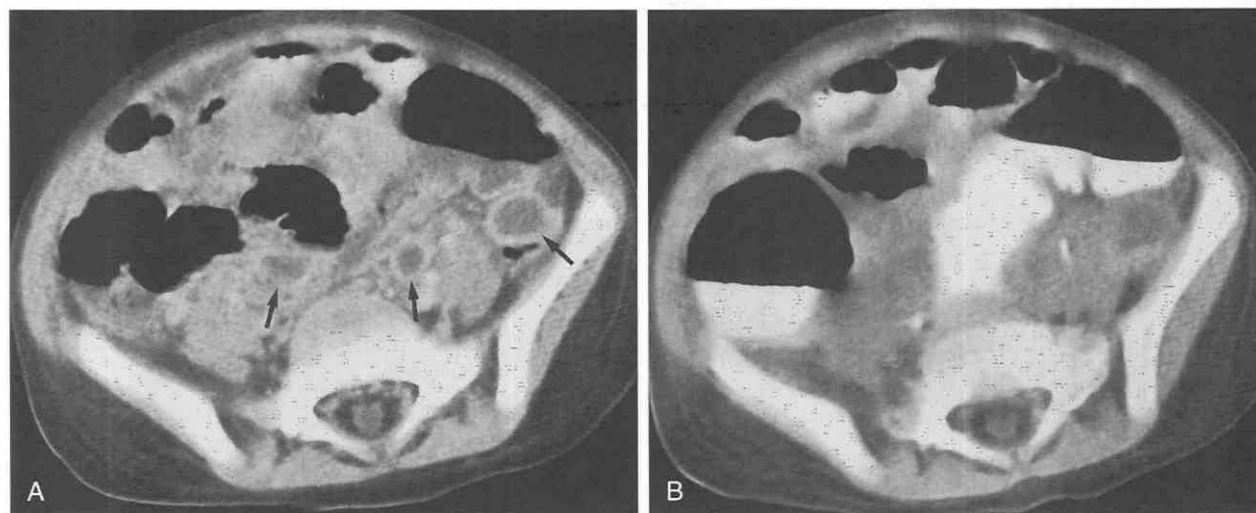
Complicated appendicitis in a 3-year-old girl. *A*, Axial CT scan at the level of the upper pelvis following administration of oral and intravenous contrast material. There are several interloop abscesses (*arrows*). More anteriorly, it was difficult to distinguish intestine from inflammatory change. *B*, After administration of 360 mL of rectal contrast material, it is clear that colon occupied the region in question. There were no abscesses that were amenable to percutaneous drainage.
